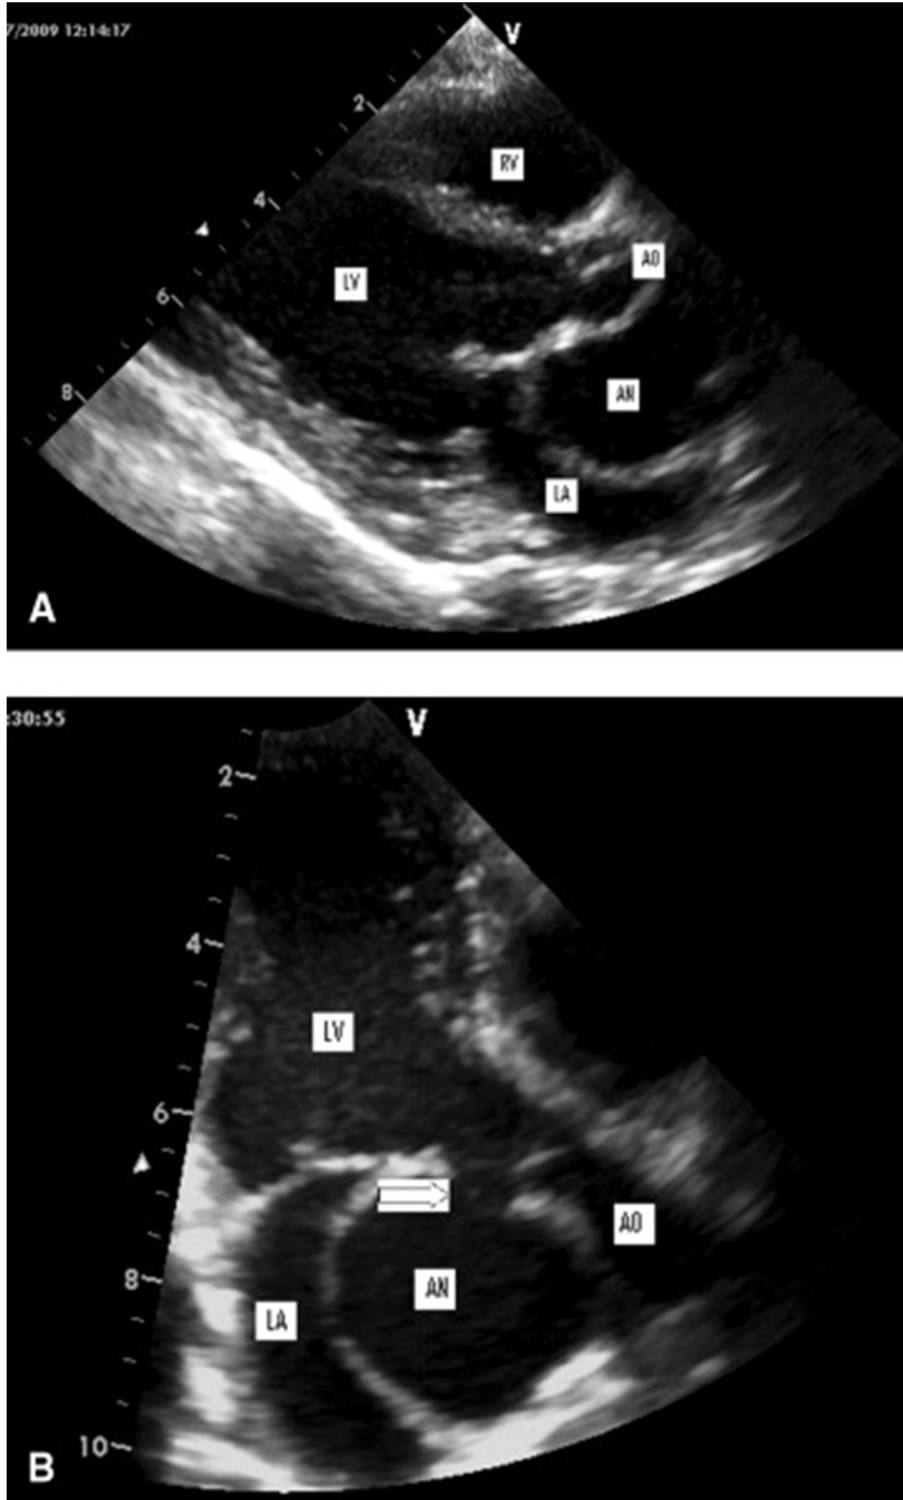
Repeat transthoracic echocardiogram 3 months after presentation. (A) Modified parasternal long-axis view demonstrating a large subaortic aneurysm. (B) Modified apical three-chamber view demonstrating the large subaortic aneurysm compressing the left atrium (LA). The opening of the aneurysm is seen just below the aortic valve (arrow). (AN = aneurysm; AO = aorta; LV = left ventricle; RV = right ventricle.)
